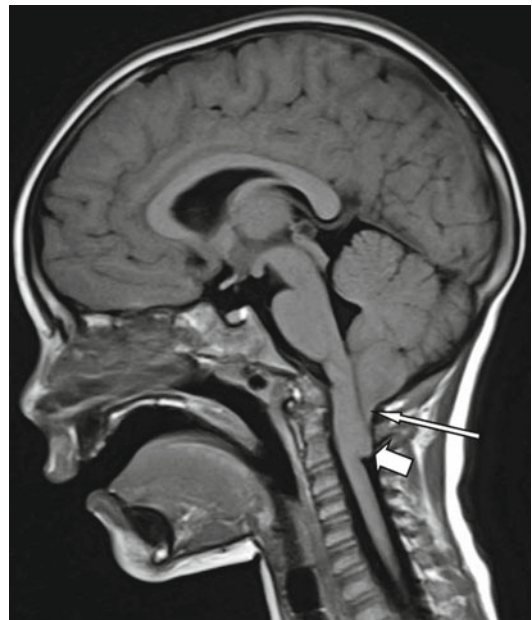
Sagittal T1-weighted MRI. Note the pointed cerebellar tips (*long arrow*) often seen in the Chiari I malformation and elongation of the brainstem (*short arrow*)
